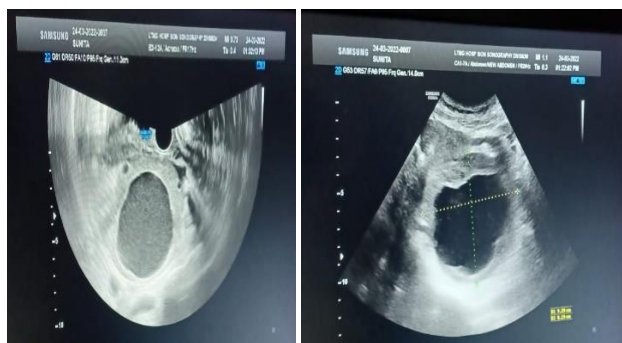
Ultrasound figures of an ovarian hemorrhagic cyst.
